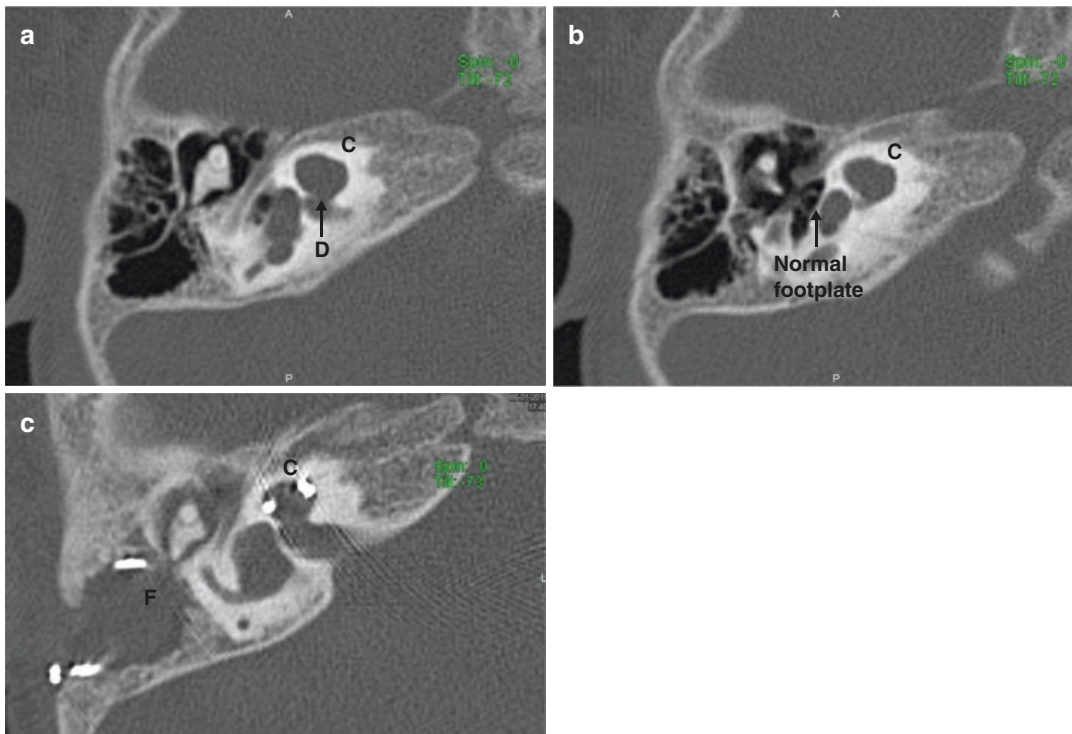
Bilateral IP-I with defective fundus between cochlea and IAC. (a) Preoperative HRCT showing normal IP-I defect without footplate fistula or cyst, and normal
